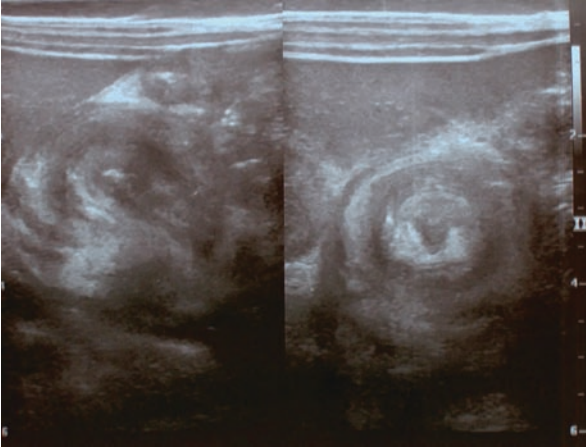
Sonographic images of intussusception. On the *left*: longitudinal plane showing “pseudo-kidney sign.” On the *right* a transverse plane showing the “target sign”
